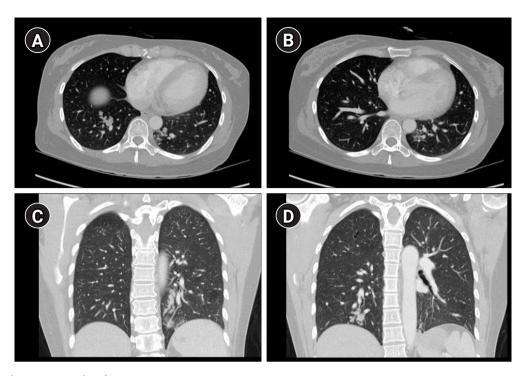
Axial (A, B) and coronal (C, D) views of the chest computed tomography show clustered nodular and tubular opacities, as well as tree-in-bud appearances in both the lungs.
